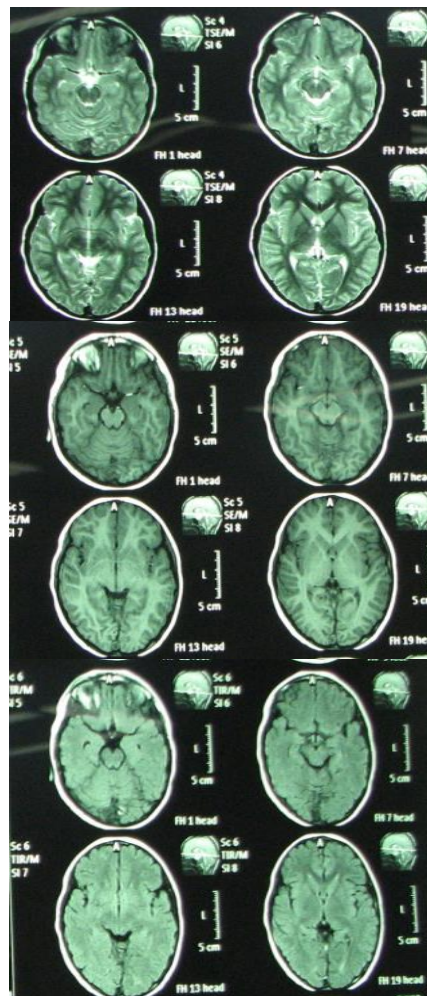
Brain MRI of patient with hemorrhagic thrombosis and nephrotic syndrome
